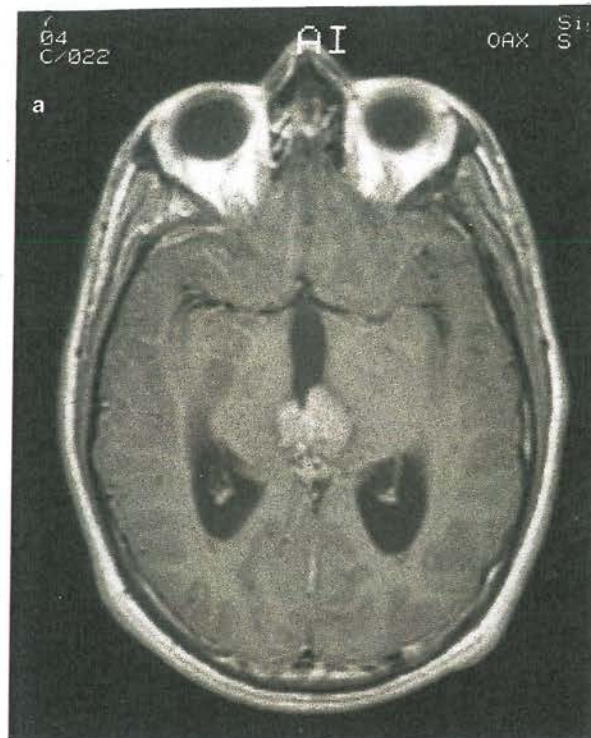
Pineal mass seen on T1-weighted MRI scan. (a) Axial view; (b) sagittal view – note dilated ventricles
